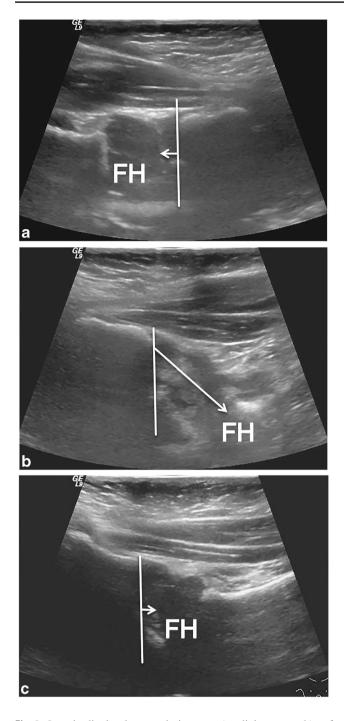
Longitudinal ultrasound images (medial approach) of both proximal femurs in a 5-month-old boy with bilateral dislocated developmental dysplasia of the hip obtained one week after closed reduction (a-c). The right femoral head is in the acetabular fossa, and the PFD=4.0 mm (a). The left femoral head is not reduced and is located posterolateral to the acetabular fossa. PFD=21.1 mm (b). There were many abnormal hyperechoic shadows in the left acetabular fossa. After clinical manipulative reduction, a repeat ultrasound examination confirms reduction of the left femoral head, with a PFD value of 3.8 mm (c). *FH* femoral head, *PFD* pubo-femoral distance
